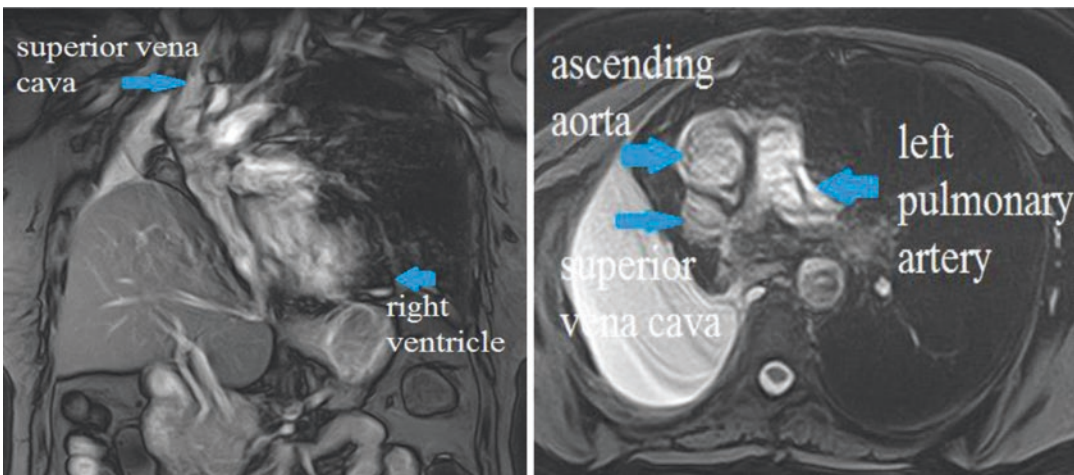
Thoracic MRI Right pneumonectomy with cardiac displacement on the right side (1 year follow-up)
